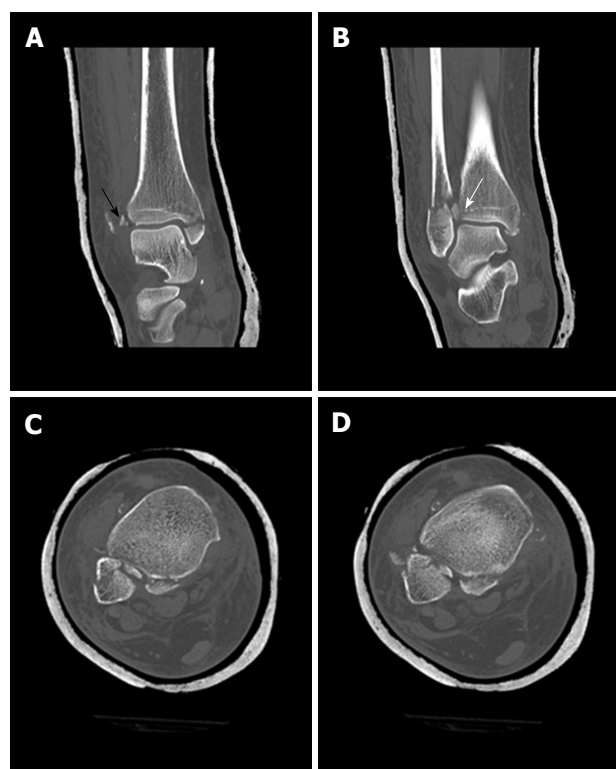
Computed tomography scans of the ankle from Figure 8 showing tibial avulsion of the anterior tibiofibular ligament with dislocation of a bone fragment (black arrow) too small for screw fixation (A), complete closed reduction was not possible due to a small bone fragment (white arrow) interposed between distal tibia and fibula (B), displaced avulsion of a small fragment of the posterolateral malleolus (C, D).
